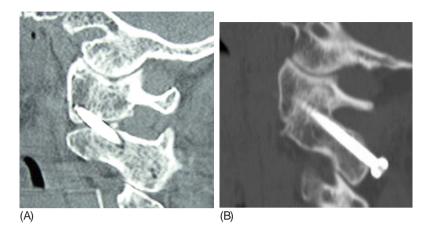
Fusion of the atlanto-axial joint on CT after surgery.
